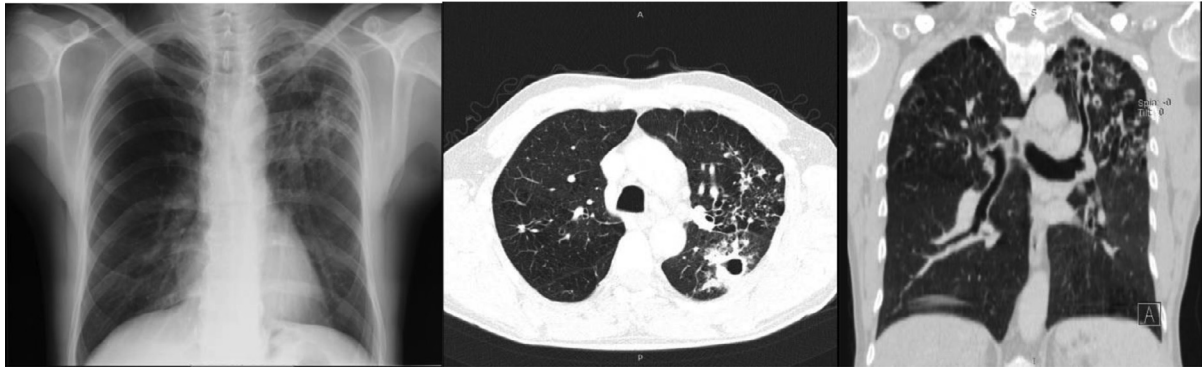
First chest radiography and MSCT conducted soon after the onset of the first symptoms
